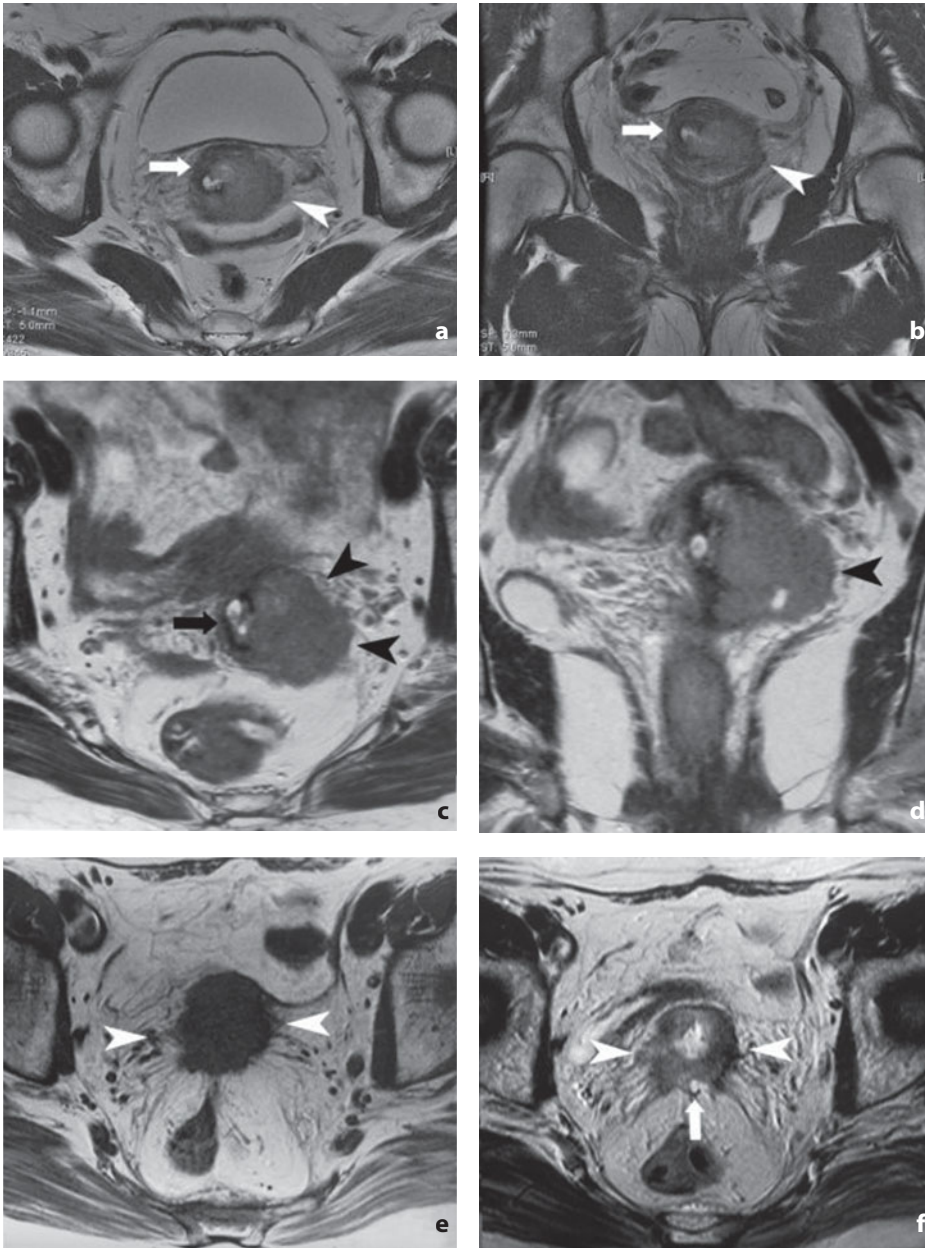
Magnetic resonance. Cervical cancer, stage IIB. Axial (a) and coronal (b) T2-weighted images show initial invasion of the left parametrium (*arrowhead*) subsequent to neoplastic invasion of the cervical stroma which appears partially conserved on the right (*arrow*). c,d Images show a case where invasion of the left parametrium (*arrowhead*) is more evident. Note the intact cervical stromal ring and the right parametrium (*arrow*). e,f Images show carcinoma invading both left and right parametrium. Diagnosis is possible on the basis of the spiculated tissue (*arrowheads*) penetrating the pericervical adipose tissue. Involvement of the mesorectal fascia is also evident (*arrow*)
